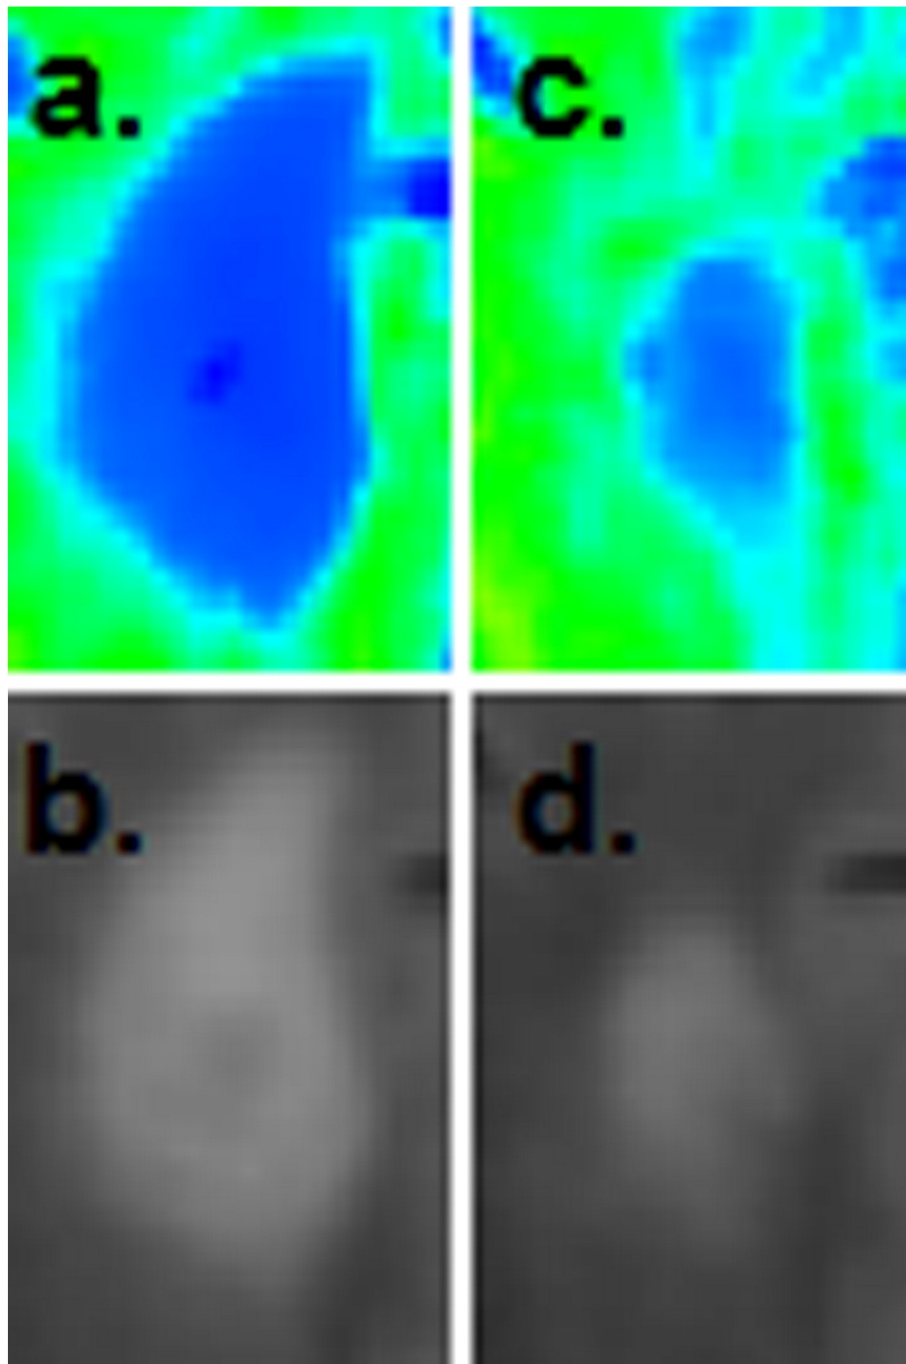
An example of an enhancing lesion that demonstrated a large improvement in MWF. (A) Baseline T2-FLAIR image and the corresponding MWF map. (B) Follow up T2-FLAIR image and its corresponding MWF map 6 months later (212% improvement). Partial resolution of the lesion can be appreciated on both the T2-FLAIR and MWF images (inset).
